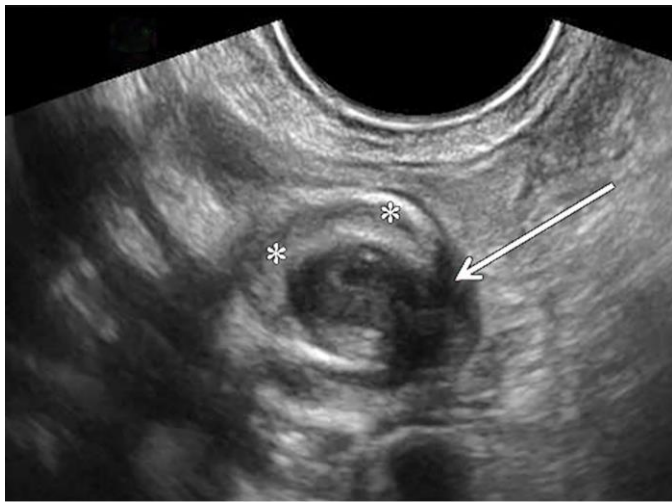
(left): 39-year-old woman with appendiceal intussusception secondary to endometriosis. Findings: Transvaginal ultrasound of the right iliac fossa demonstrates a hypoechoic nodule with posterior shadowing (arrow). Adjacent to this nodule is the appendix, invaginated centrally within the cecum (asterisks). Technique: Transvaginal ultrasound using 7 MHz endocavity, curvilinear probe. (Reprinted by permission: Chamié LP, Ribeiro DMRF, Tiferes DA, et al. Atypical sites of deeply infiltrative endometriosis. Clinical characteristics and imaging findings. Radiographics 2018;38:309-328.)
